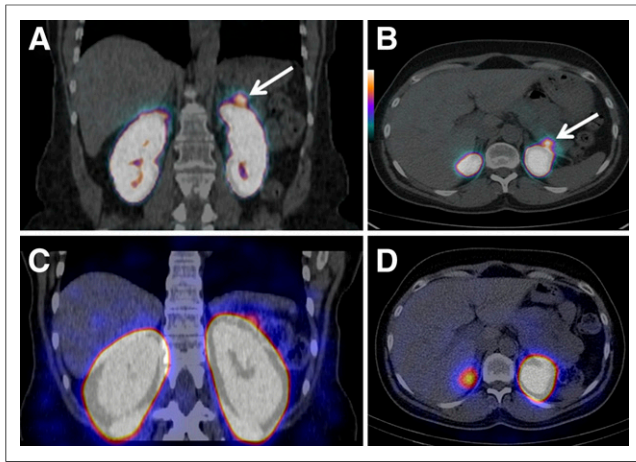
(A and B) Coronal (A) and transaxial (B) PET/CT images from patient 5 obtained 2.5 h after injection of 76 MBq of ^{68}Ga -DOTA-exendin-4. (C and D) Coronal (C) and transaxial (D) SPECT/CT images of same patient 72 h after injection of 66 MBq of ^{111}In -DOTA-exendin-4. Arrows show focal ^{68}Ga -DOTA-exendin-4 uptake in distal pancreatic tail consistent with surgically removed insulinoma. SPECT/CT did not show the insulinoma.
